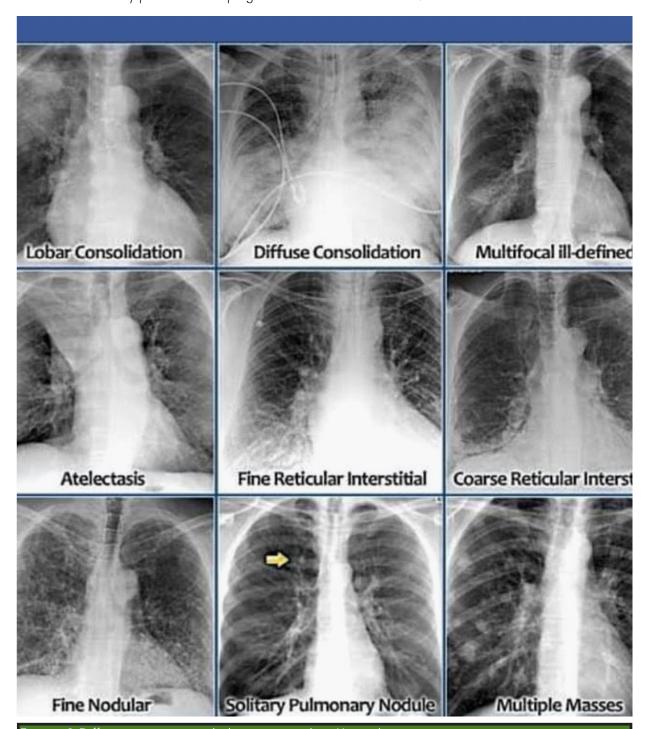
Different common pathologies noticed on X-ray chest
